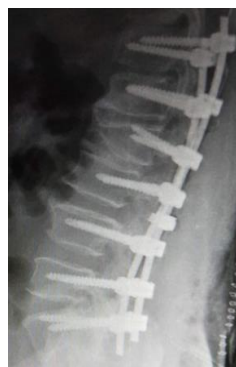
x-ray L-S spine lateral view with OVF showing long segment pedicle fixation
